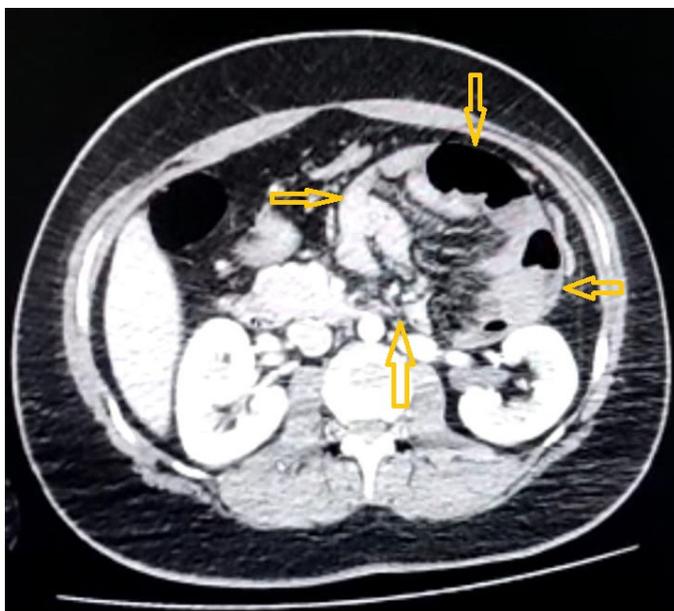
Computed tomography of the abdomen at first admission (yellow arrow)
